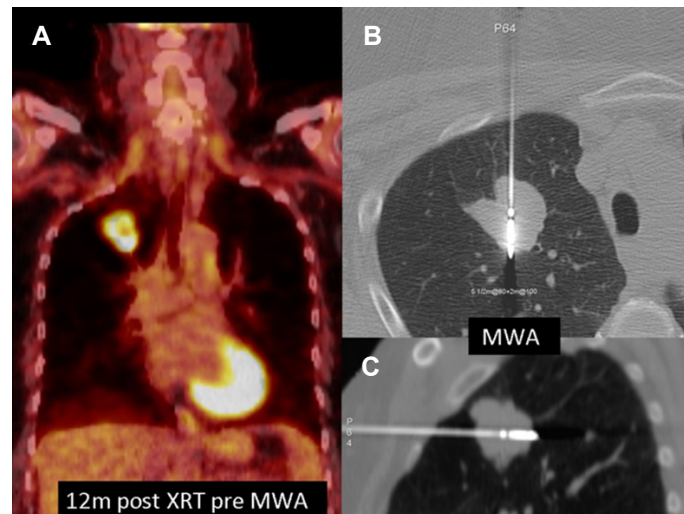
57-year-old female with RUL SCC. A: Coronal FDG-PET scan 12 months post definitive radiotherapy (58 Gy) RUL T2N0 SCC; B, C: microwave antenna (Acculis standard pMTA) centrally within the tumour; a total of 7 min 30 s ablation time-5 min 30 s at 80 W followed by 2 min at 100 W. RUL: right upper lobe; SCC: squamous cell carcinoma
